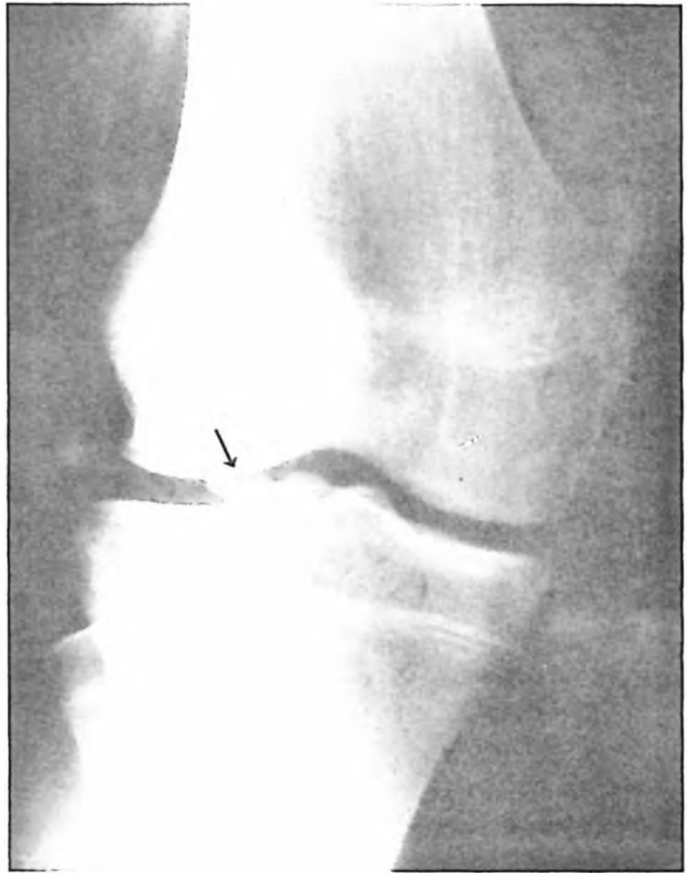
Plain X-ray showing osteochondritis dissecans of the lateral femoral condyle.
